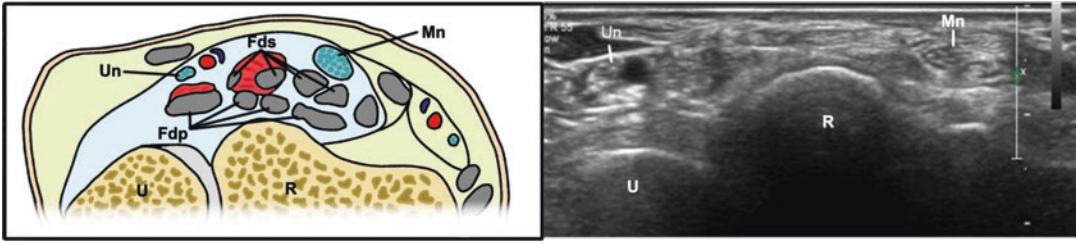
Axial ultrasound image—normal anatomy at the DRUJ; *R* radius, *U* ulna, *Mn* median nerve, *Un* ulnar nerve, *Fdp* flexor digitorum profundus, *Fds* flexor digitorum superficialis
